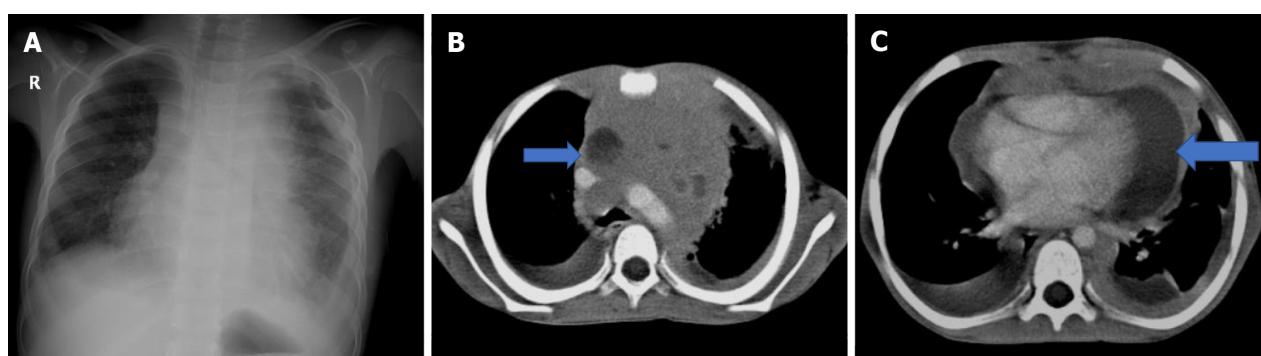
A 5-year-old patient with T-cell ALL has neck and back pain, shortness of breath, and cough. A: On posteroanterior chest radiograph, significant enlargement of the mediastinum secondary to the mass and increased aeration in the right lung are observed; B: Compression of the right main bronchus secondary to the mass (red arrow) also draws attention; B and C: A mass lesion (red arrow) located in the anterior mediastinum but extending into the middle mediastinum and circulating the main vascular structures is observed.
